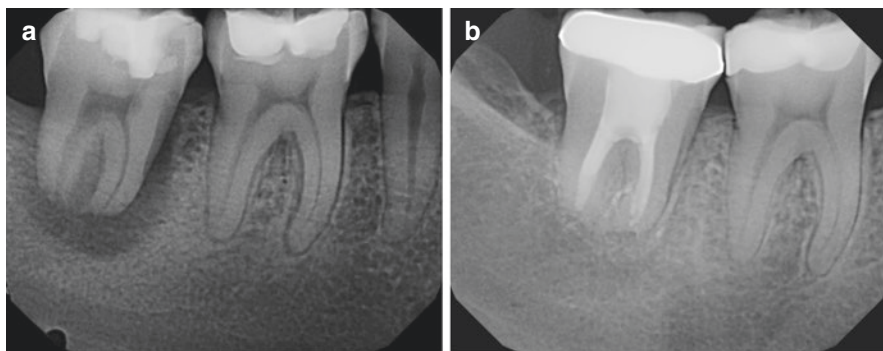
Lesions of primary endodontic origin periodontal status. (a) Preoperative radiograph of tooth #31. The tooth was nonresponsive to pulp sensibility testing and exhibited grade 2 mobility. Although probing depths ranged from 3.0 to 5.0 mm, the cervical periodontal attachment appeared to be intact circumferentially. A draining buccal sinus tract was present. The diagnosis was primary endo lesion (pulp necrosis with chronic apical abscess) with an unfavorable prognosis. The patient was highly motivated to try to save the tooth, and initial response to pulp debridement and placement of interim calcium hydroxide paste was favorable. RCT was completed in two appointments. (b) Good healing and bone regeneration are apparent at the 18-month posttreatment evaluation (Case courtesy of Dr. Cristina Olarov). (c) Heavily restored tooth #30 was nonresponsive to pulp sensibility testing. The tooth was slightly sensitive to percussion, palpation, and biting. Mobility was WNL. A periodontal probe could be inserted to full length of probe in a single, isolated mid-buccal defect. The diagnosis was primary endo lesion (pulp necrosis and chronic apical abscess). (d) Favorable initial healing was observed at the 1-year posttreatment evaluation and all probing depths are now WNL
